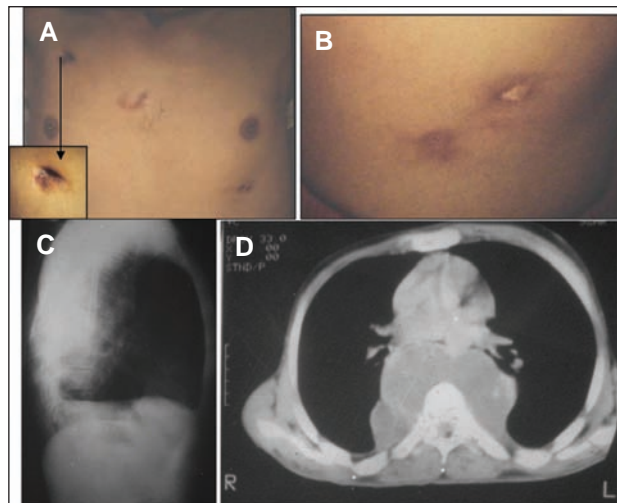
A) Puckered scars of old TB gummata at right axillary fold, sternum, and left infra-mammary area. B) The 2 presenting TB gummatous lesions on the left flank. C) Chest X-ray, lateral view showing clear lung fields, posterior mediastinal mass and normal vertebral column. D) Chest CT scan showing posterior mediastinal cystic swelling with normal vertebral column.
